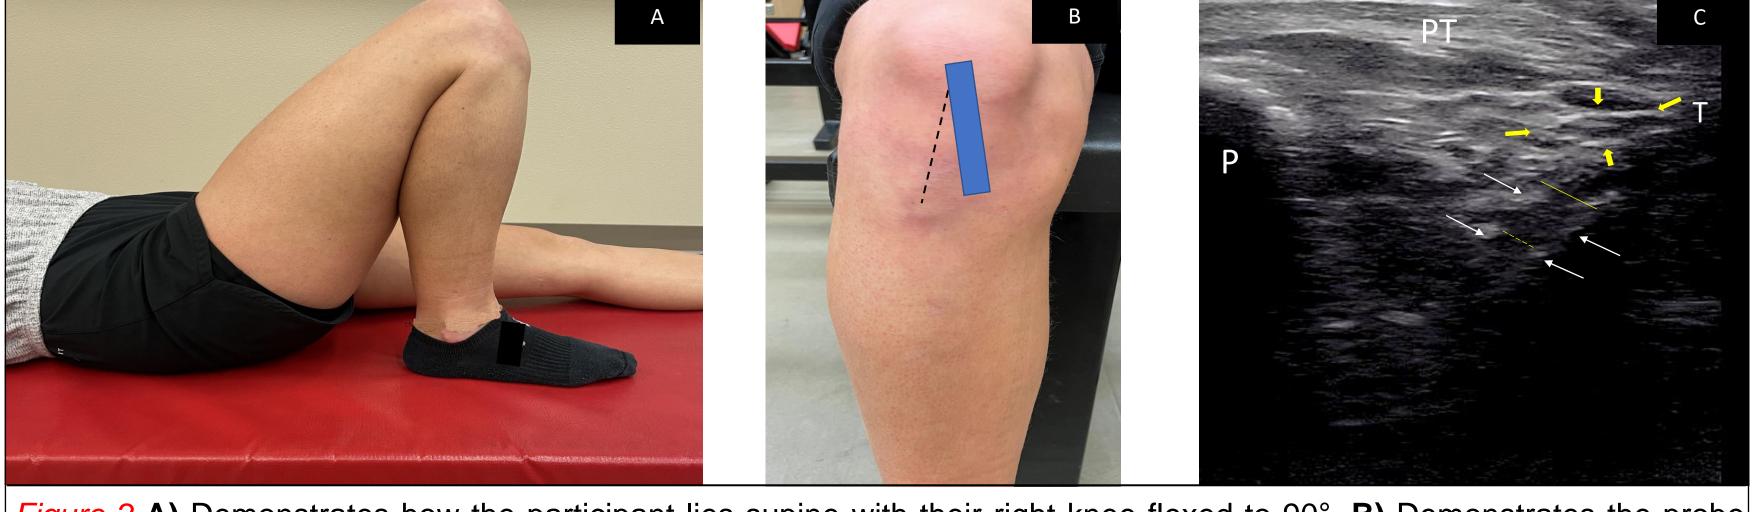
A) Demonstrates how the participant lies supine with their right knee flexed to 90°. B) Demonstrates the probe position for visualizing the ACL. The blue rectangle represents the probe, and the black dotted line represents the patella tendon. Probe is placed above the patella tendon and rotated 30°. The inferior part of the probe is medial to the patella tendon and the superior part of the probe is lateral to the patella tendon. C) Ultrasound imaging of the ACL at the long-axis view of the infrapatellar area. The ACL can be viewed between the white arrows and the dotted line represents the anteromedial bundle diameter and the solid line represents the full ACL diameter. The yellow arrows outline the transverse ligament which is used as a guide to identify the ACL. PT, patellar tendon; P, patella; T, tibia.
